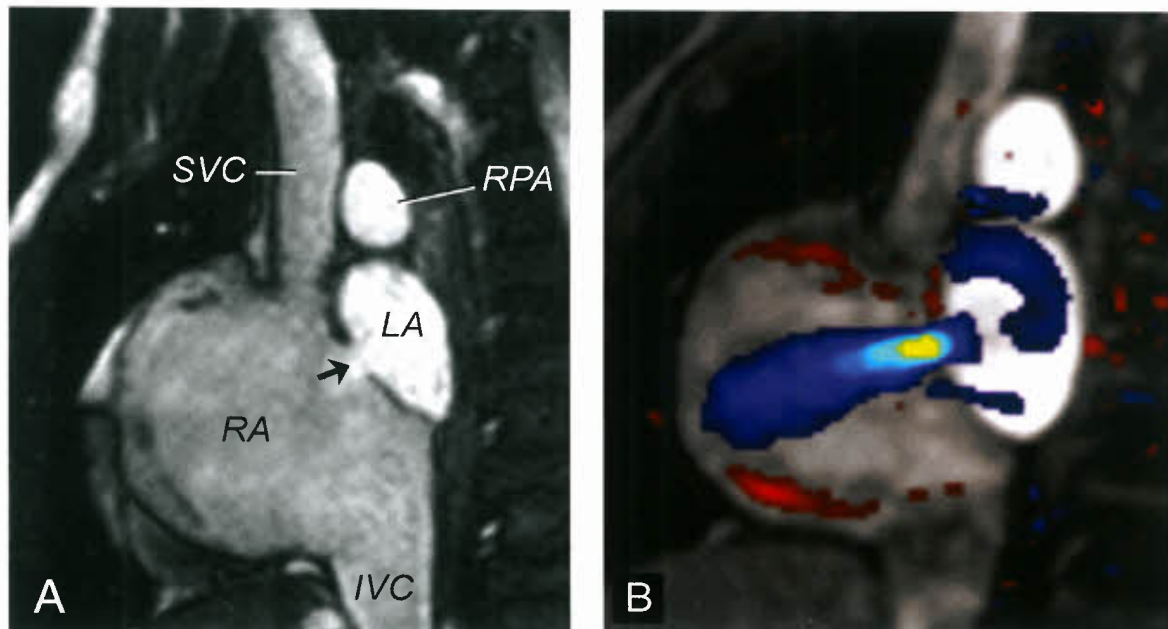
Secundum ASD. A: Oblique sagittal SSFP image showing a centrally located defect (arrow); B: Color-coded phase-velocity cine MRI showing flow from the left atrium (LA) to the RA through the defect. LA, left atrium; IVC, inferior vena cava; RA, right atrium; RPA, right pulmonary artery; SVC, superior vena cava.
